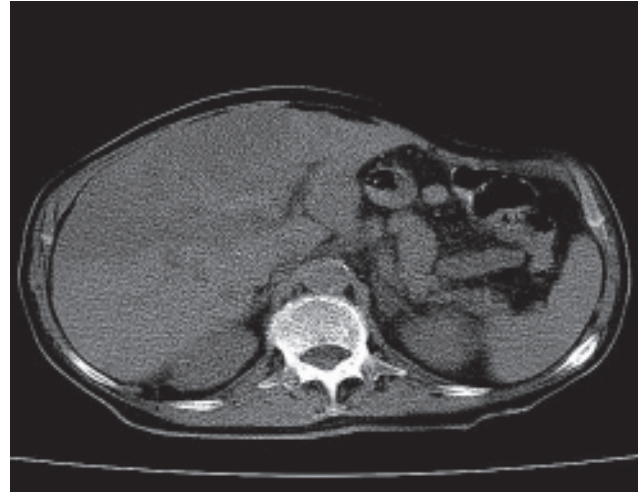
Contrast-enhanced CT. The fatty liver parenchyma appears hypodense as opposed to the splenic parenchyma.
